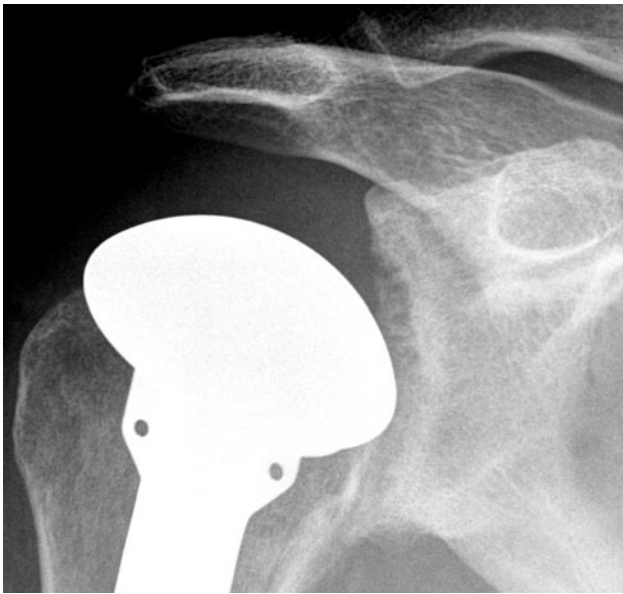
Case 2: Anteroposterior radiograph of right shoulder 47 months after index operation with humeral implant hemiarthroplasty.
